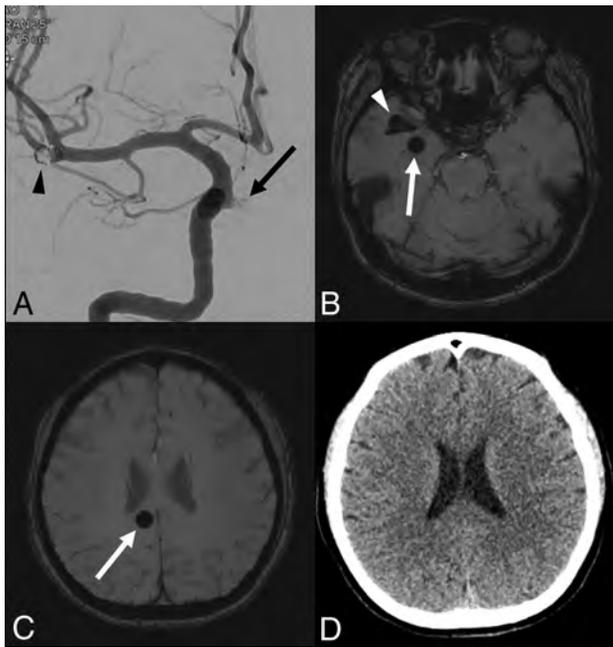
A, Coil embolization of 2 aneurysms arising from the right ICA (arrow) and MCA at the bifurcation (arrowhead). B, SWI 6 months later demonstrates a 10-mm rounded dark-signal lesion within right temporal lobe (arrow) and another dark signal representing a coil mass and stent (arrowhead). C, A second rounded dark-signal lesion (10 mm) is present within the right corpus callosum (arrow). D, The lesion of right corpus callosum is undetectable by postprocedural CT.
